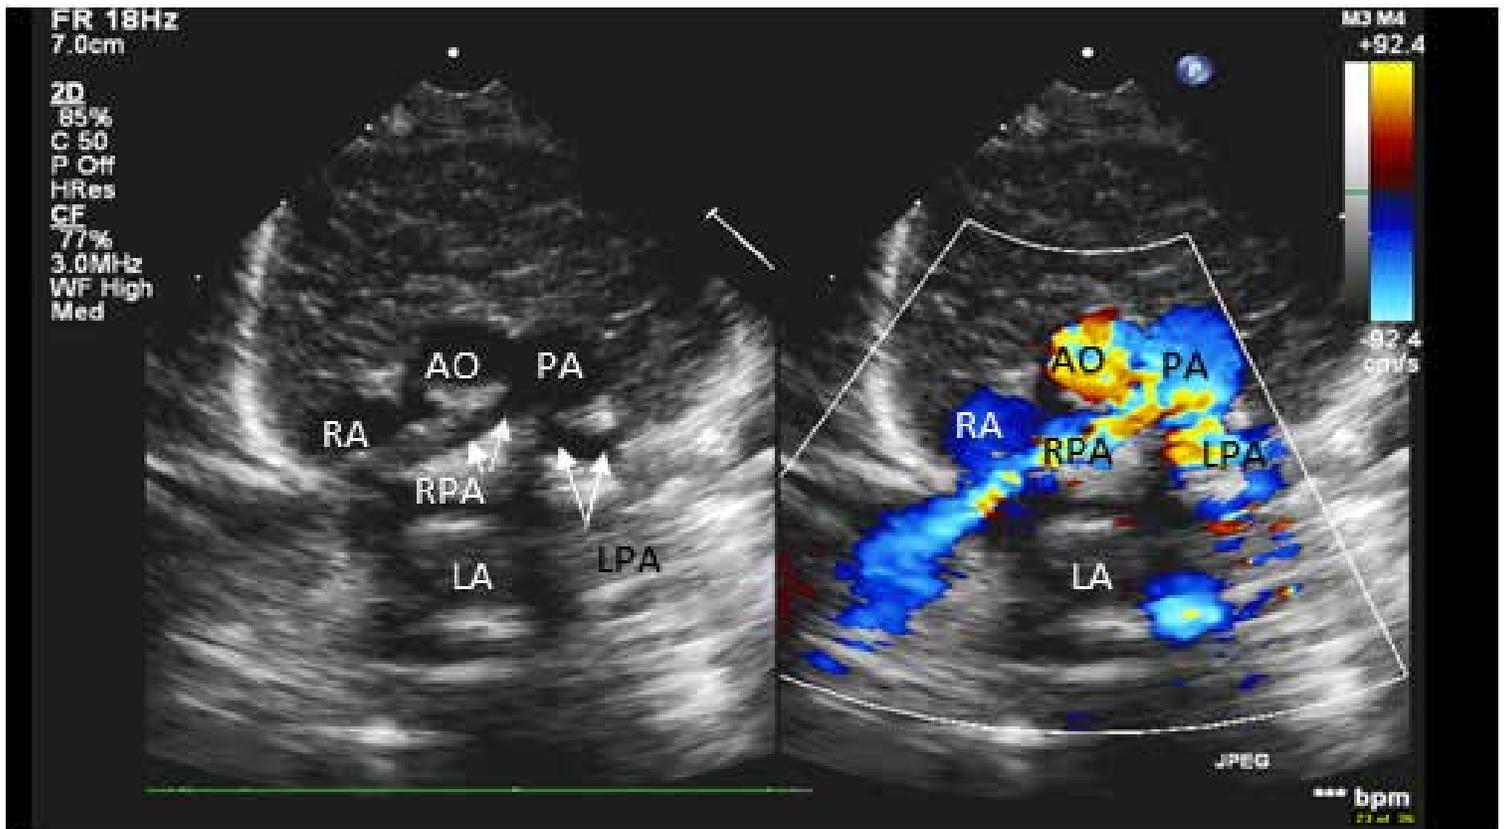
A 2D echo with color Doppler depicting pulmonary artery (PA), right pulmonary artery (RPA), and left pulmonary artery (LPA) in high parasternal view. AO; Aorta, RA; right atrium, LA; left atrium
